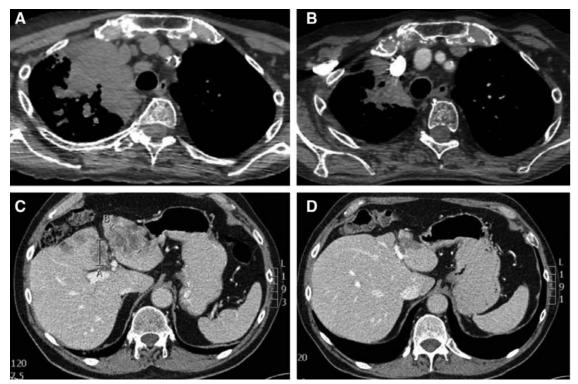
Patient examples. A and C, Baseline computed tomography scans of two different patients with lung adenocarcinoma and V600E. B and D, Follow-up computed tomography scans showing tumor remissions after 3 months of therapy with vemurafenib.
